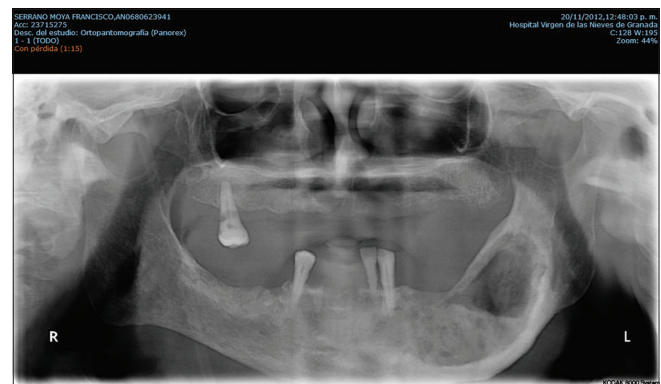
Orthopantomogram of mandibular intraosseous odontogenic squamous cell carcinoma
